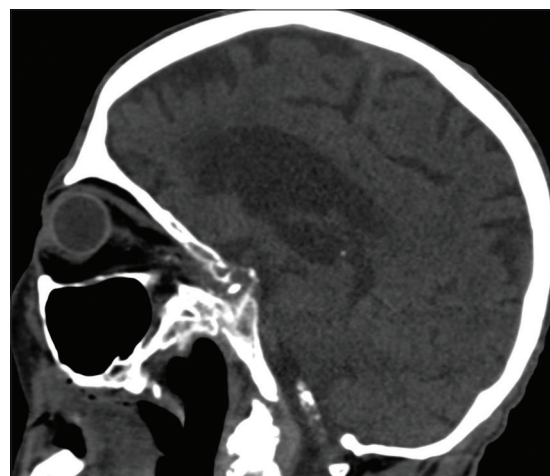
Sagittal cranial computed tomography shows a hyperdense lesion dorsal to the basion of the clivus
